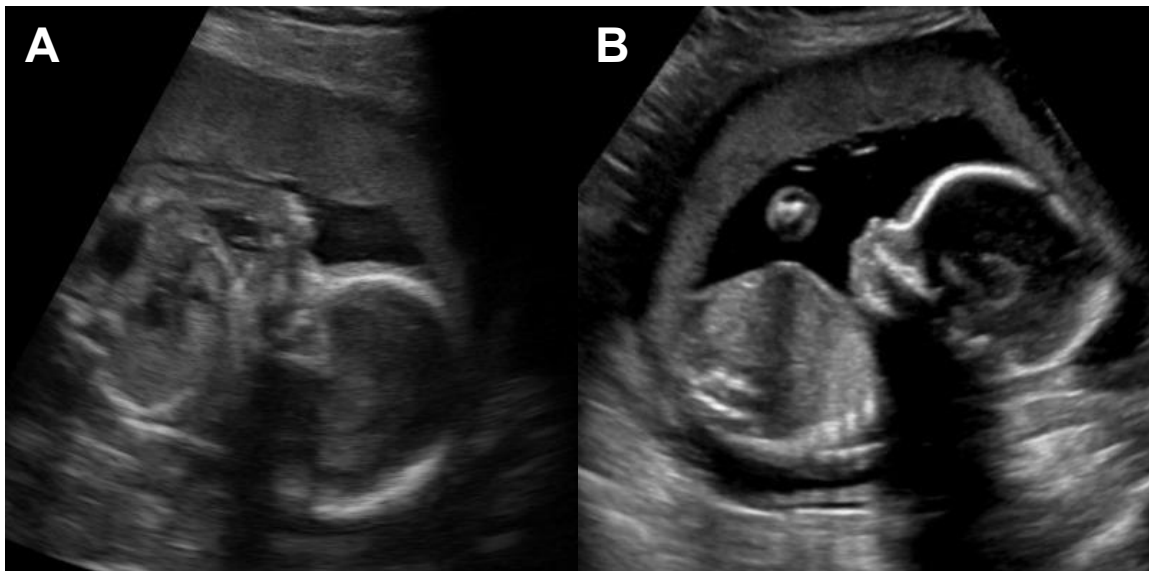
Representative images demonstrating fetal profile using the (A) telerobotic ultrasound system and (B) conventional ultrasound system. Ultrasound exams were performed at 20 weeks 4 days and 20 weeks 0 days, respectively.
